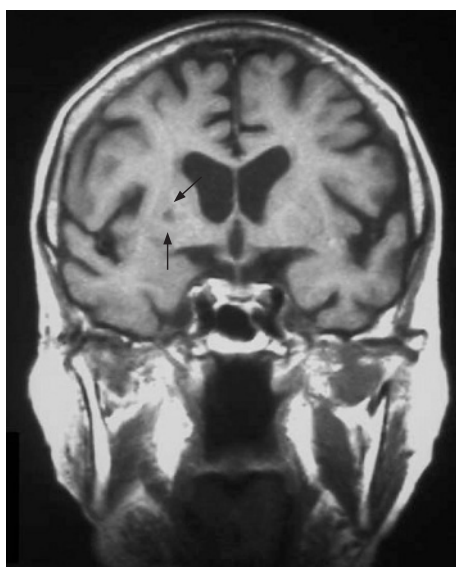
Coronal section magnetic resonance image showing a right putamenal lacunar infarct (arrows) and corticosubcortical atrophy. Head of the caudate nucleus is not affected.
